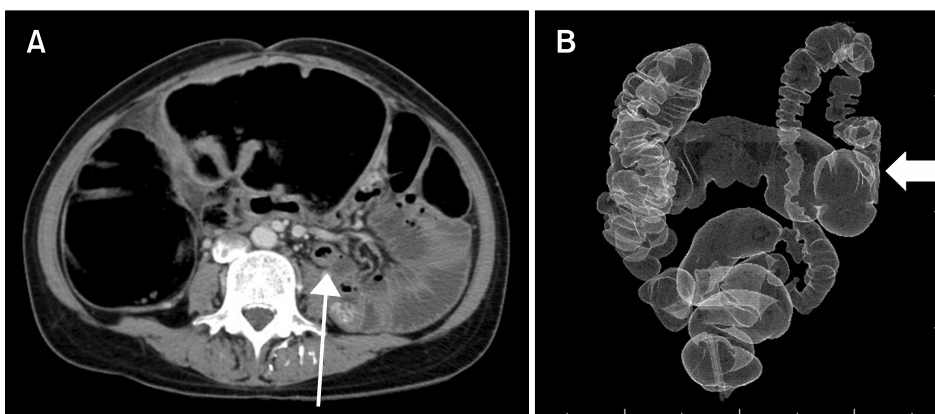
Abdomen pelvis computed tomography (CT) scan (A) and CT endoscopy (B) shows dilatation of the ascending and transverse colon. The arrows indicate the transition zone at the level of the splenic flexure with no evidence of mechanical obstruction.
